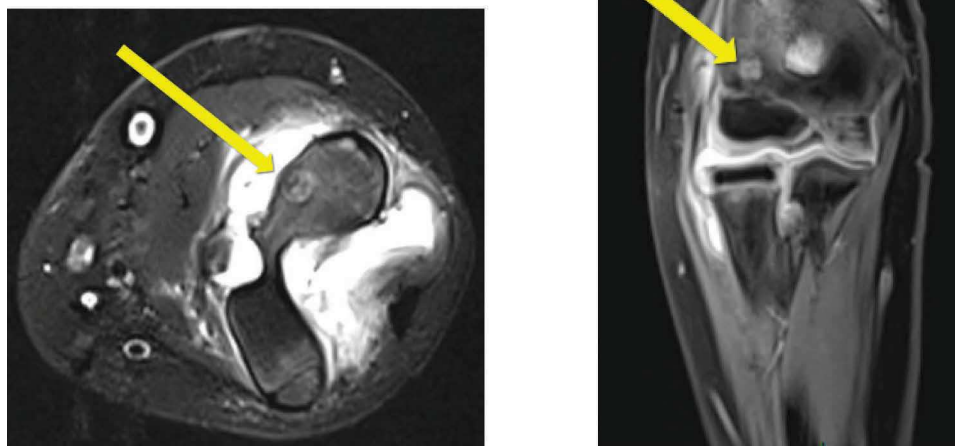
Magnetic resonance imaging of the osteoid osteoma. The arrows show a small, heterogeneous, well-defined, 5 mm lacunar lesion located in the lateral part of the left humeral metaphysis.
